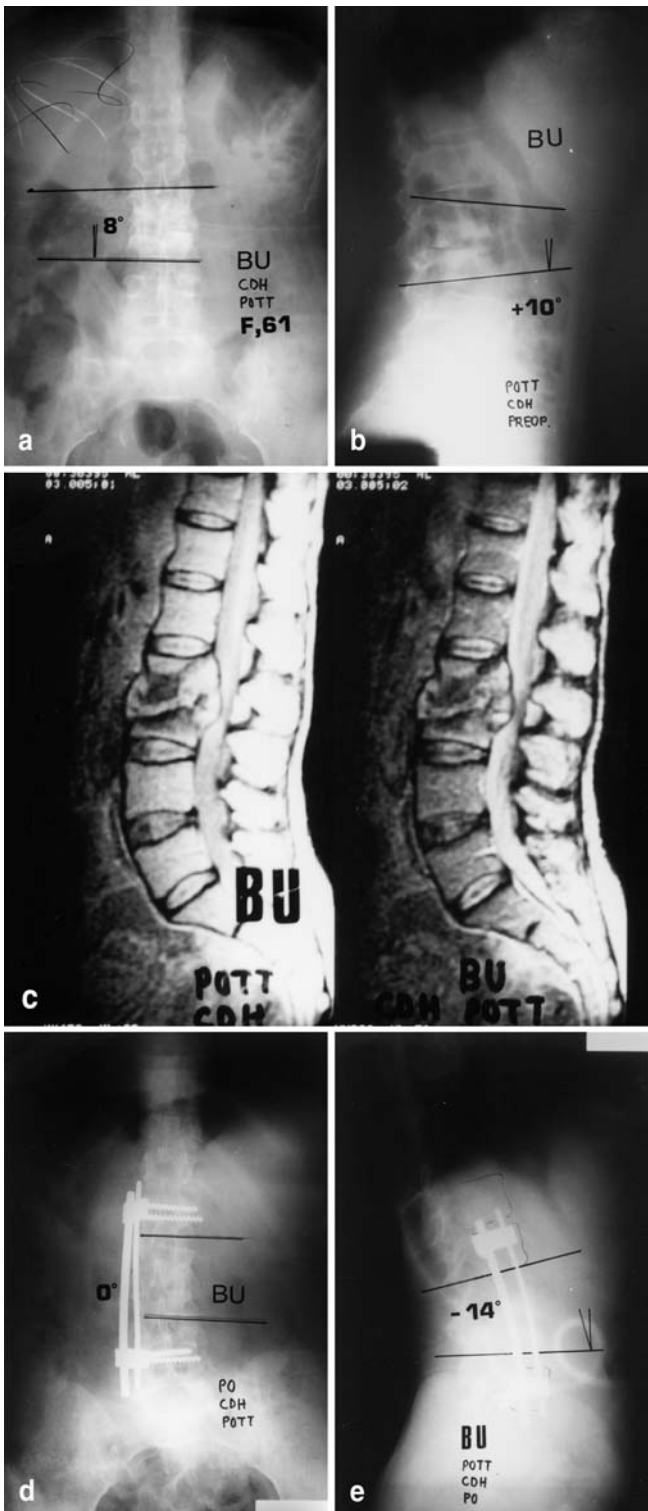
A 61-year-old man (B.U.) with Pott's disease in the L2–3 vertebrae. Three mobile segments were instrumented with anterior CDH and a 66.7% correction rate in the sagittal plane and 100% correction rate in the frontal plane were obtained after anterior radical debridement and strut grafting. There was no loss of correction and solid fusion mass was observed at the last visit. Preoperative posteroanterior (A) and lateral (B) radiographs and sagittal MR image (C), and postoperative posteroanterior (D) and lateral (E) radiographs
